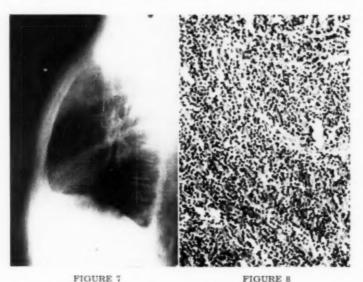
Lateral roentgenogram of plasma cell myeloma behind the sternum.
